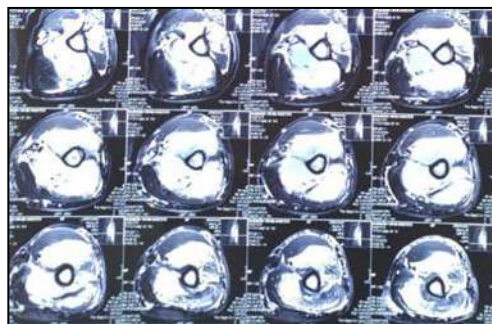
MRI report suggestive of infiltrative intramedullary enhancing pathology with marked periosteal muscle altered signal intensity and enhancement ? infiltrative neoplastic process ?? remote possibility of infective process
